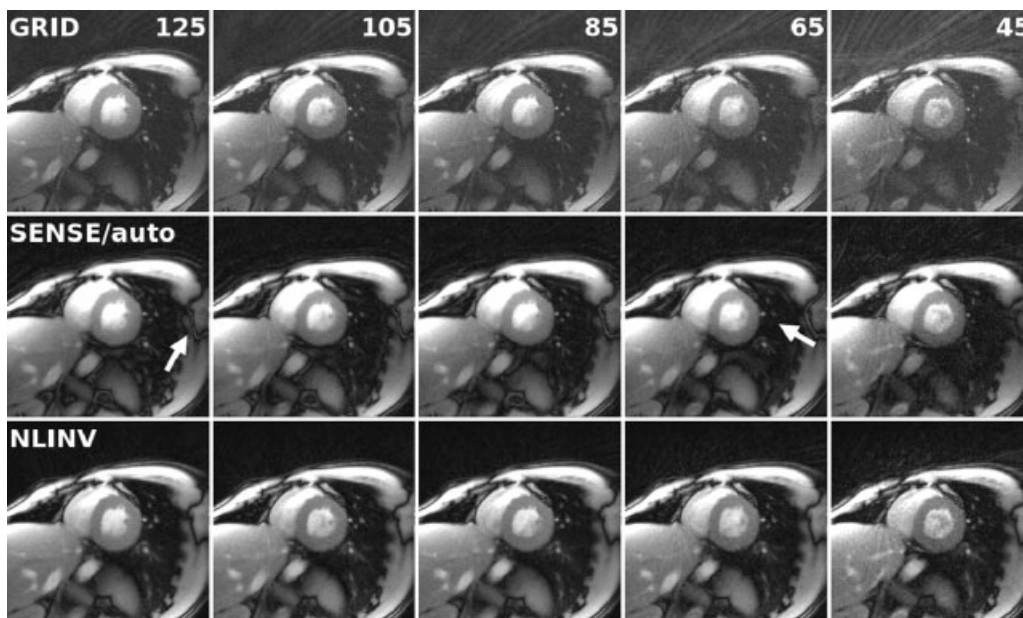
A single time frame from a real-time MRI data set of the human heart during systole reconstructed by gridding (GRID), autocalibrated SENSE (SENSE/auto), and nonlinear inversion (NLINV). The reconstructions were obtained with 125 to 45 spokes per frame. Arrows indicate reconstruction artifacts (see text). For other parameters, see Fig. 2.
